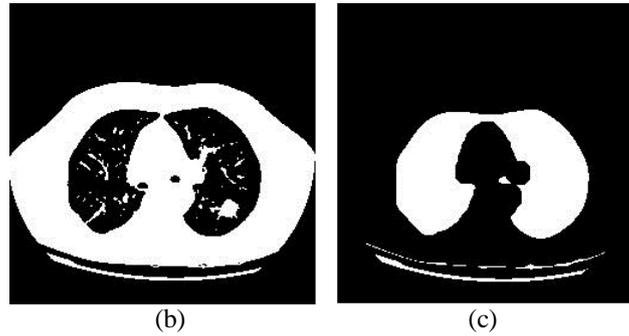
a) chest CT slice b) Lung mask formed by simple thresholding c) lung mask formed by VQ
